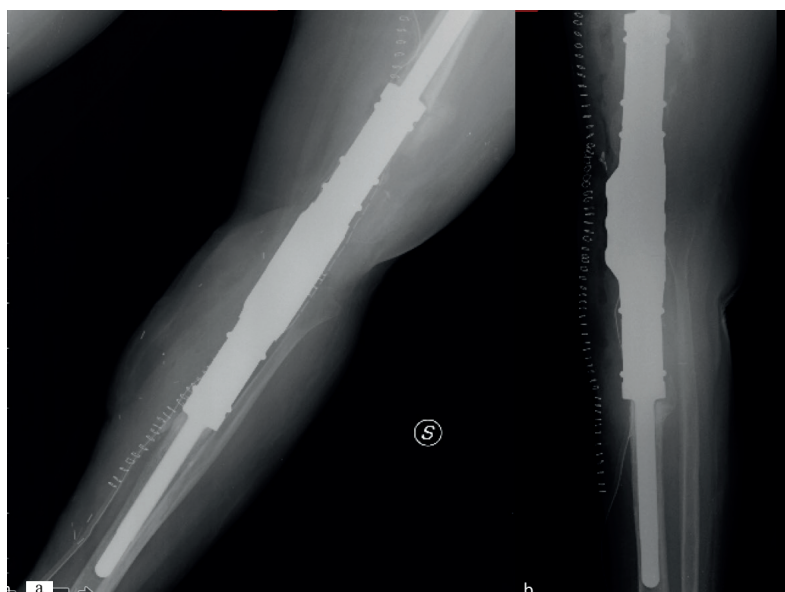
A, Post-operative X-ray of the mega-prosthesis locked in extension in antero-posterior view. B, Post-operative X-ray of the mega-prosthesis locked in extension in latero-lateral view.
